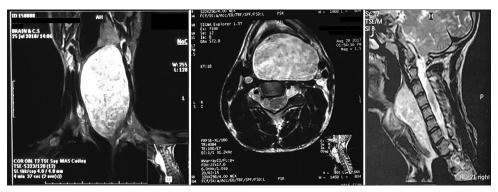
Coronal, axial, and sagittal magnetic resonance imaging demonstrating a large homogenous encapsulated mass in the left carotid space
